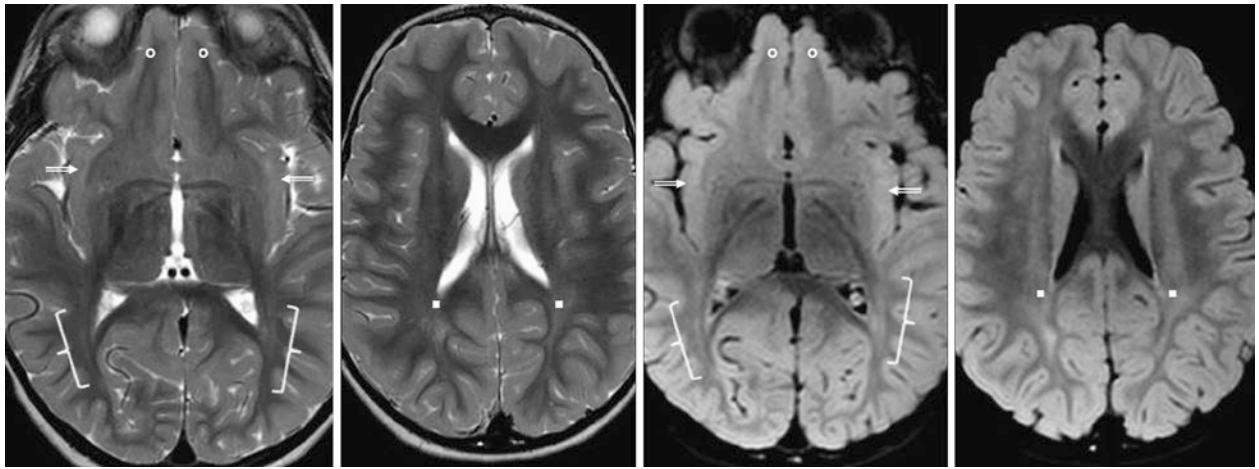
A 3.0-year-old with a fever of unknown origin had a 3T MRI with SE T2WIs (*left images*) and 3D FLAIR (*right images*). Note the mild, residual PTWM terminal zones (*squares*), as well as the optic radiations (*brackets*) and SIWM (*beveled arrows*). The OFWM (*circles*) appears mature
